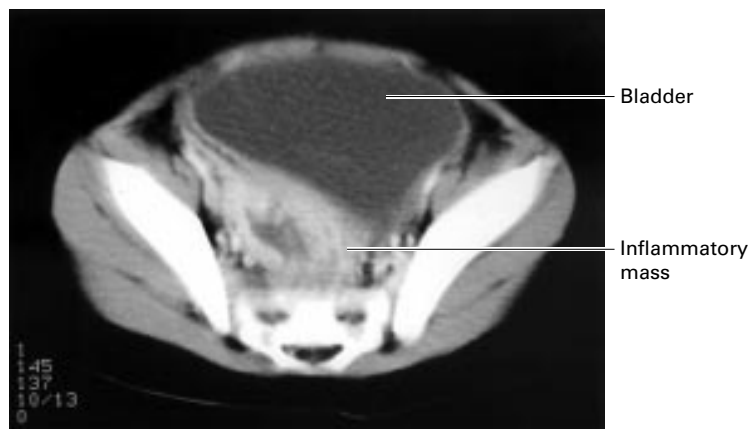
CT scan shows an enlarged bladder with an obstructed neck caused by an inflammatory mass posteriorly.
